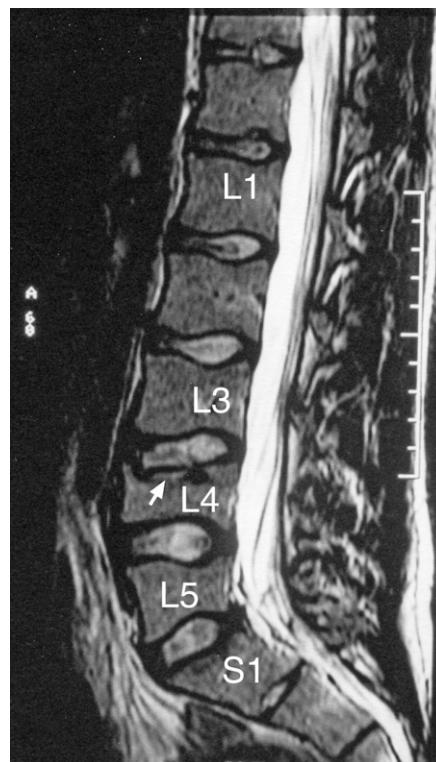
Lumbar spine MRI parasagittal T2-weighted image. Note the depression of the superior end plate of L4 (white arrow) that results in greater than 20% loss of vertical height of the anterior and mid-portions of the L4 vertebral body. As there is no evidence of oedema in the L4 body, this is an old endplate fracture that, in all likelihood, fits in with the time-frame since his accident. There is slightly reduced hydration of the L3–4 intervertebral disc.
